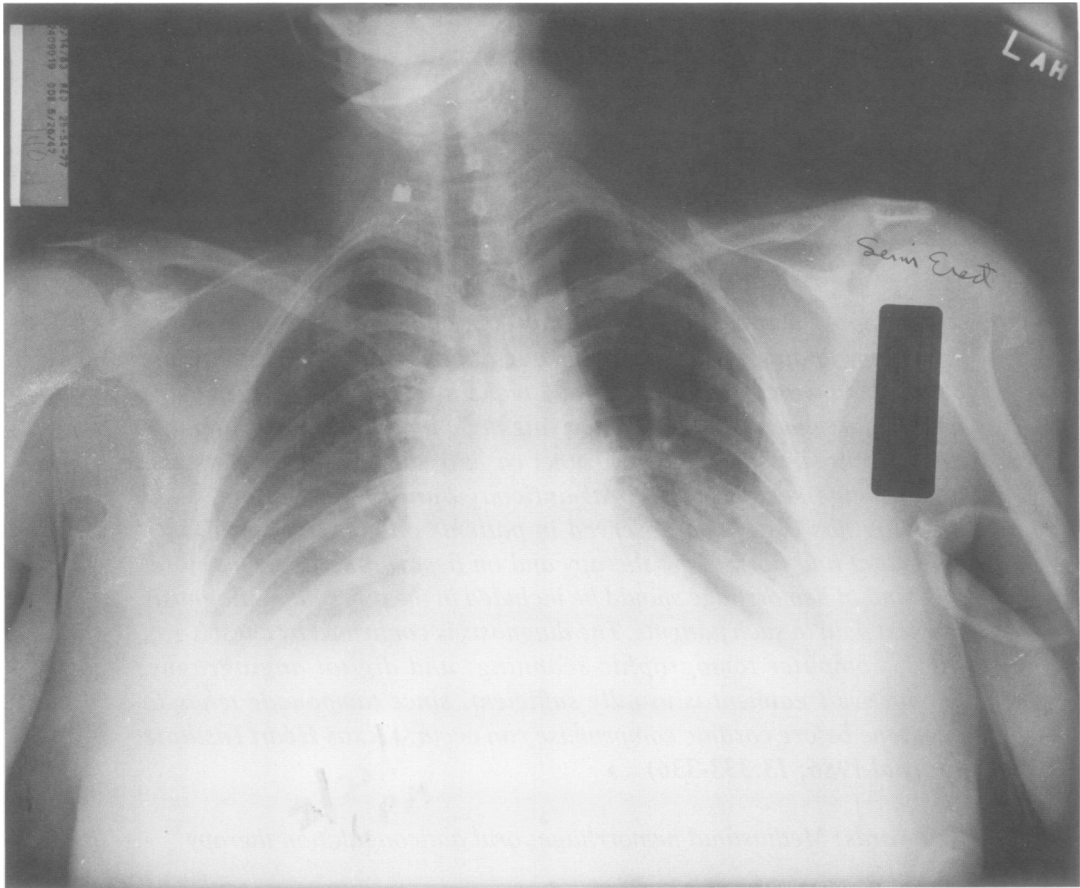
Chest X-ray film, showing a widened mediastinum and pleural effusions.
